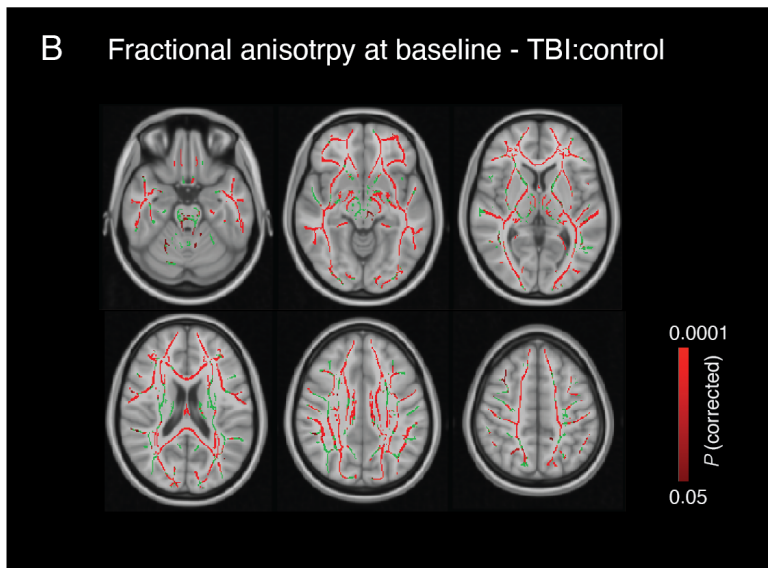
Diffusion tensor MRI evidence of axonal injury after TBI
